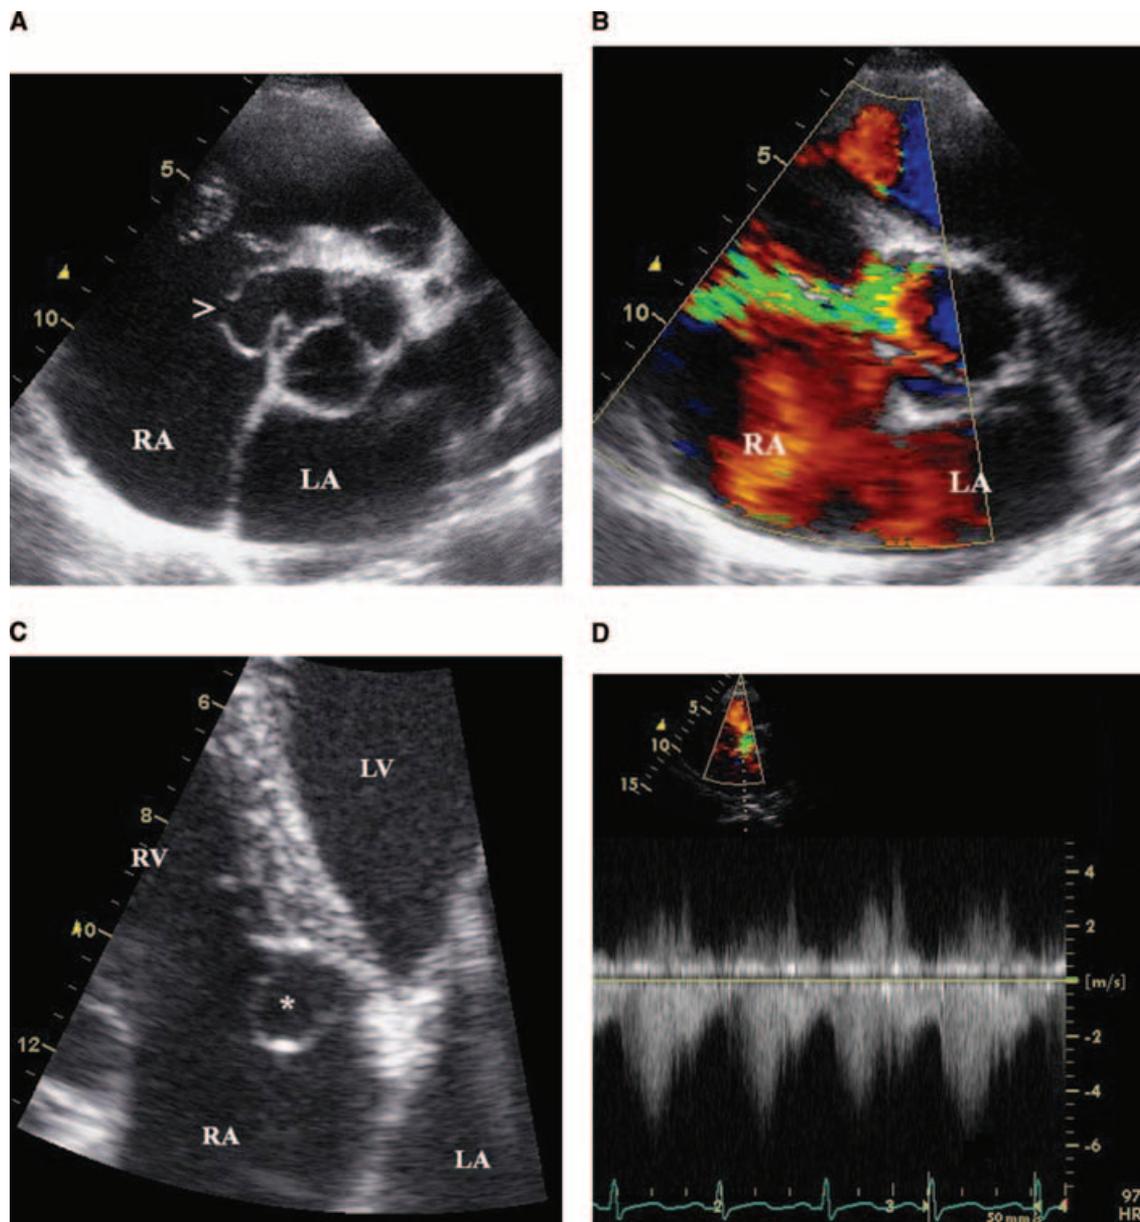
Transthoracic echocardiographic imaging of a ruptured sinus of Valsalva aneurysm. A. Parasternal short-axis at a level just above the aortic valve reveals the site of rupture within the right coronary sinus (>). B. Color flow Doppler at the same level demonstrates turbulent yellow-green flow from the ruptured sinus of Valsalva into the right atrium (RA). This turbulence was noted throughout the entire cardiac cycle. C. Close-up imaging of an apical four-chamber image reveals the aneurysm (*) within the RA above the tricuspid septal leaflet. D. Continuous wave Doppler from a parasternal short-axis view (same level as in Fig. 1A and 1B). Flow is noted throughout the cardiac cycle, but is highest during systole. LA = left atrium; LV = left ventricle; RV = right ventricle.
